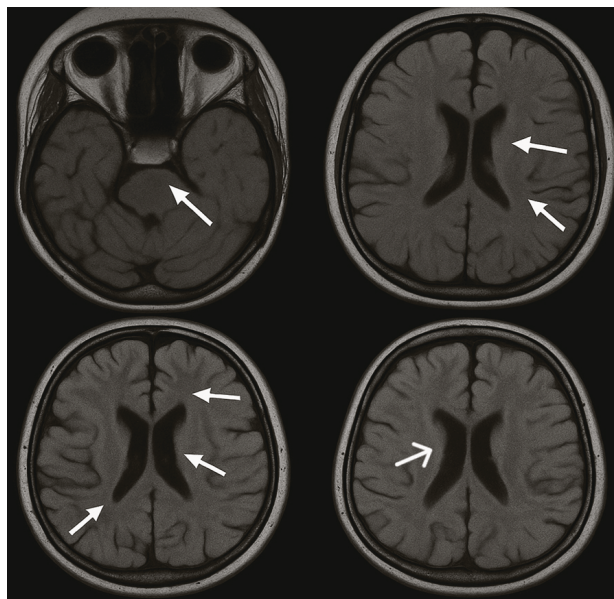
T2-Weighted Axial MRI Showing Diffuse Cortical and Subcortical Hypoxic-Ischemic Changes.
